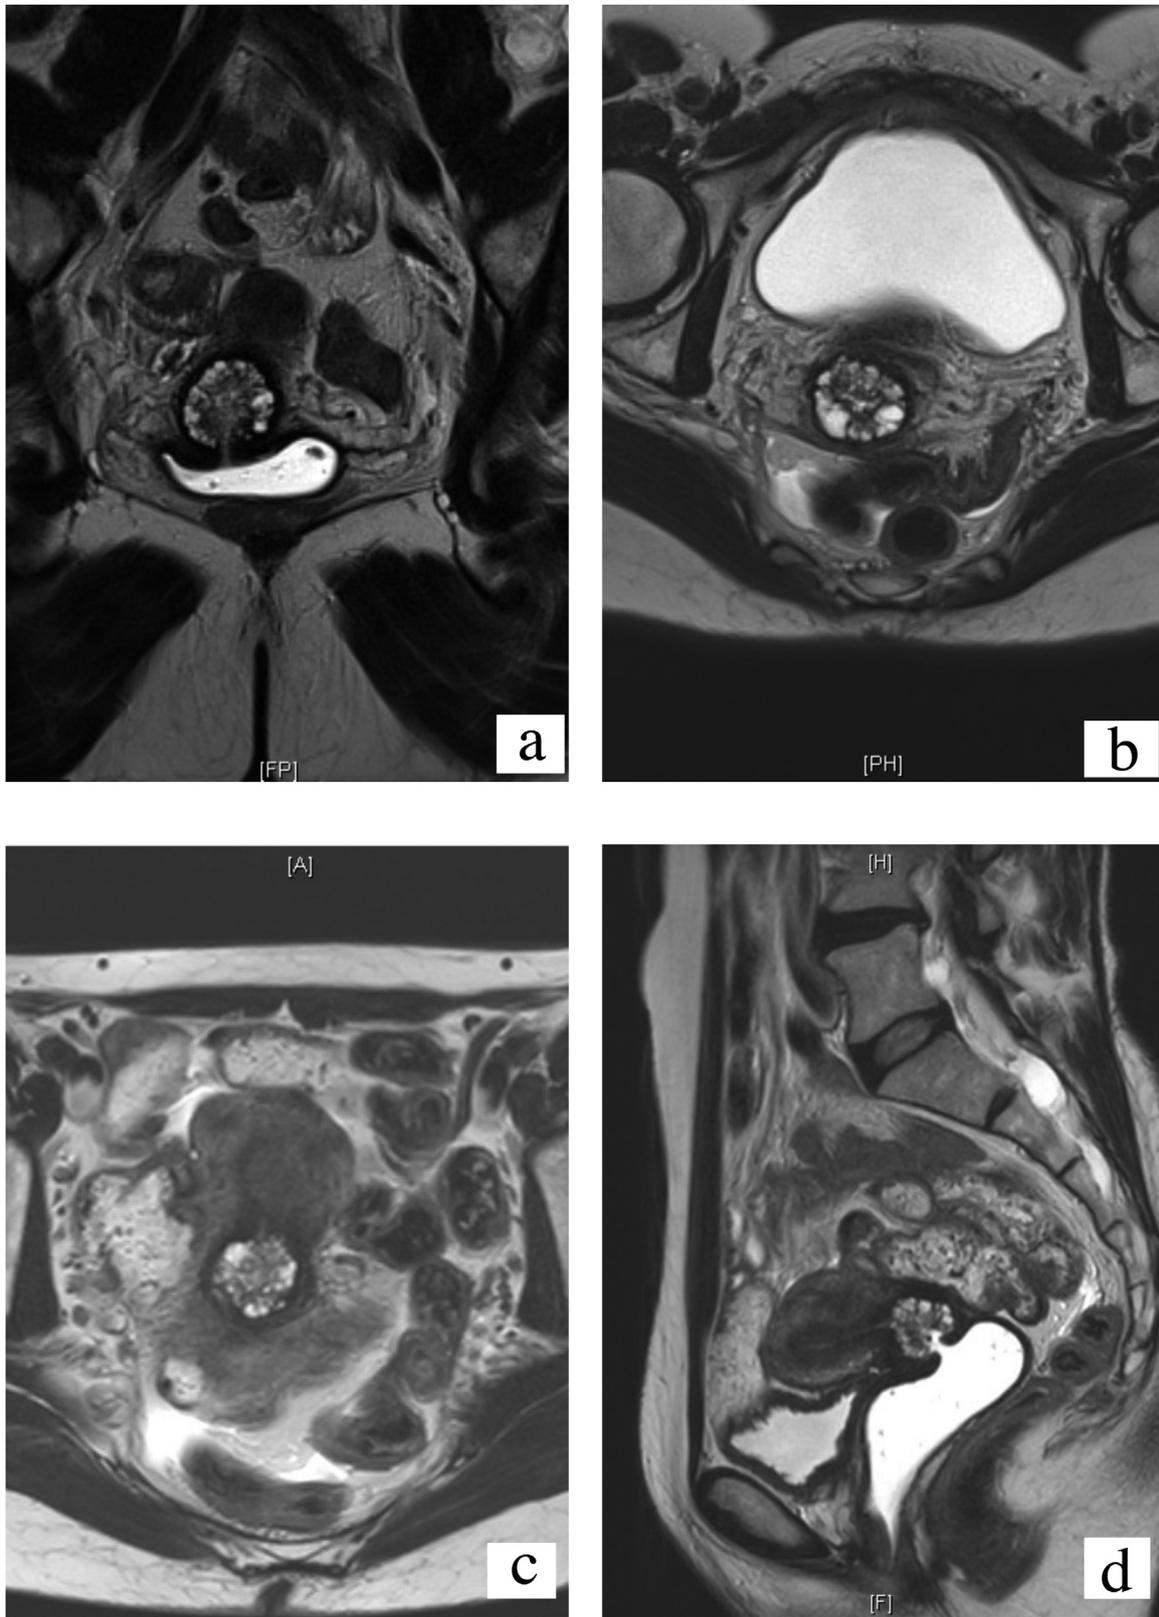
Magnetic resonance images of a minimal deviation gastric-type adenocarcinoma of the cervix: (a) coronal T2-weighted, (b, c) axial T2-weighted and (d) turbo spin-echo sagittal T2-weighted.
